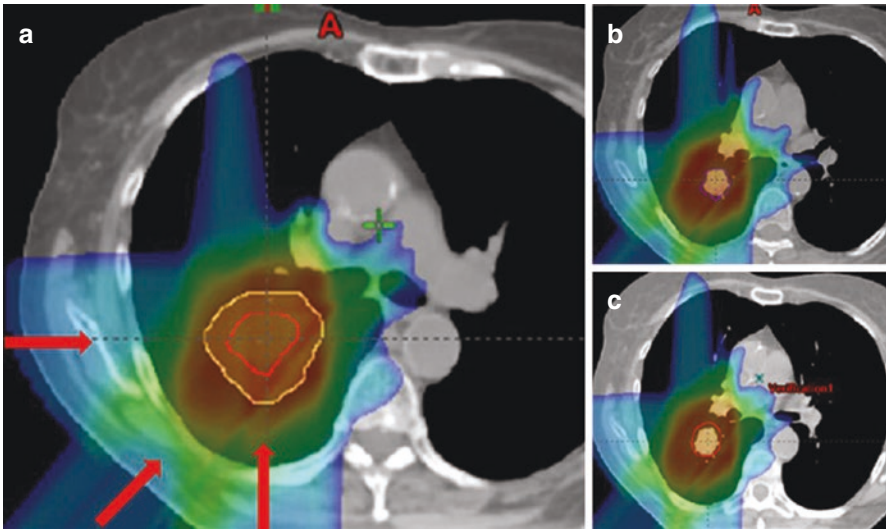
(a) Nominal plan on average CT (or mid-ventilation) dataset, with plan evaluated on (b) end-inspiration phase and (c) end-expiration phase
